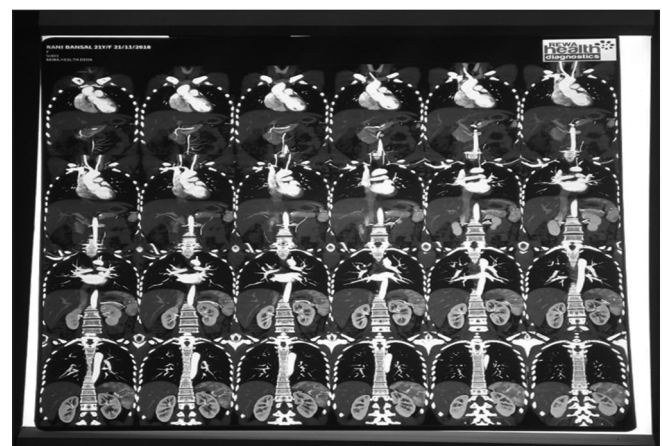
CT Angio. Chest & Upper abdomen
